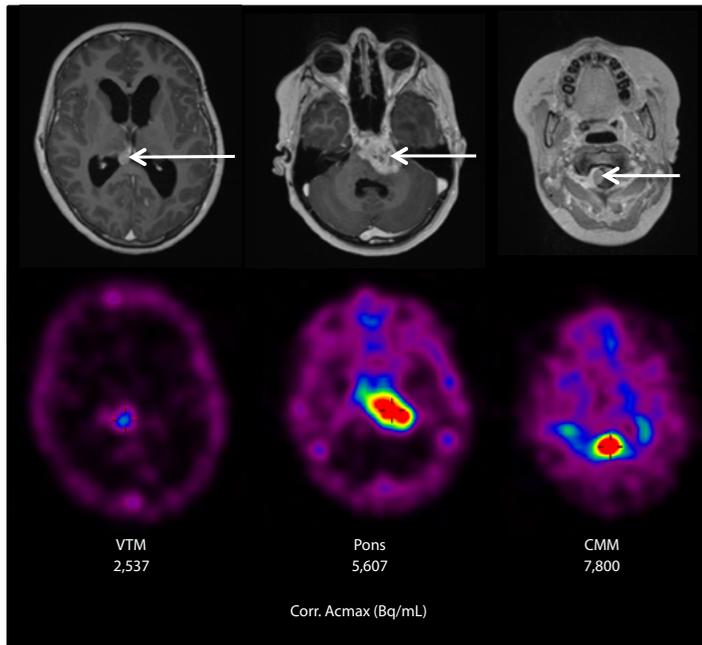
Gadolinium-enhanced T1-weighted MR images obtained 8 d before death, and corresponding PET slices obtained 4 d before death (145 h after ⁸⁹Zr-bevacizumab injection), showing primary pontine tumor and metastases in VTM and CMM.
